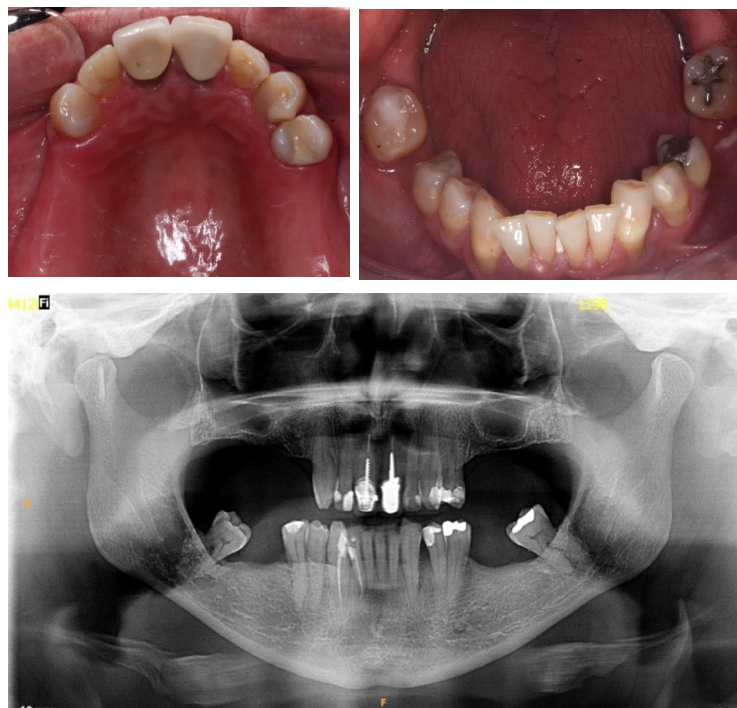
A) Occlusal view of the upper arch; B) Occlusal view of the lower arch; C) Initial panoramic radiograph.
